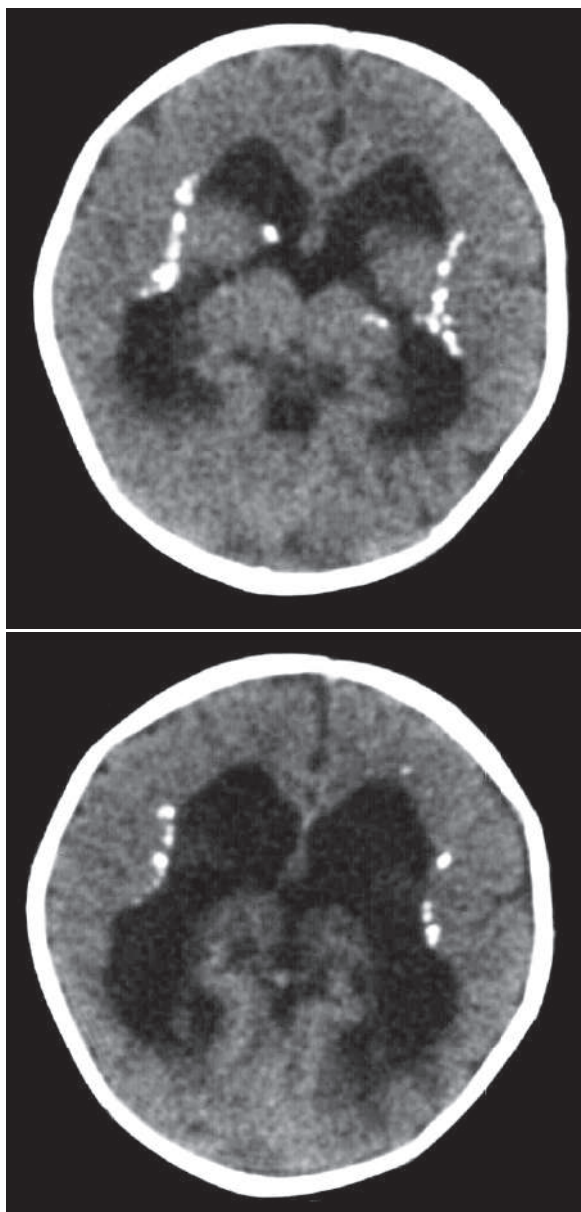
Axial nonenhanced sequential CT images of a child born with congenital toxoplasmosis show brain parenchymal atrophy, moderate ventricular system dilatation (hydrocephalus), and characteristic calcification along the ventricular edges
